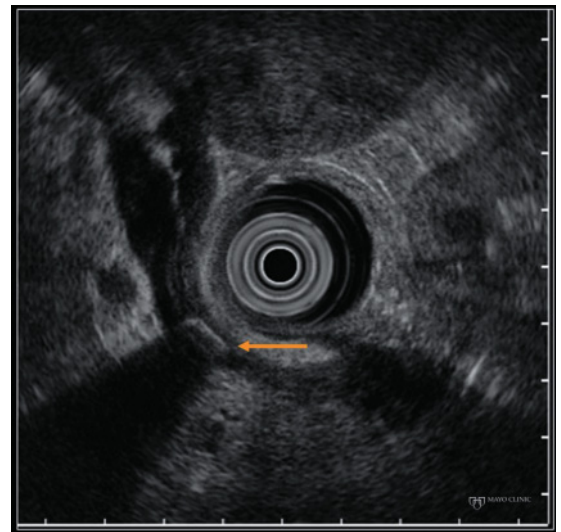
Radial endoscopic ultrasound view of a common bile duct stone (arrow) with associated post-acoustic shadowing.
